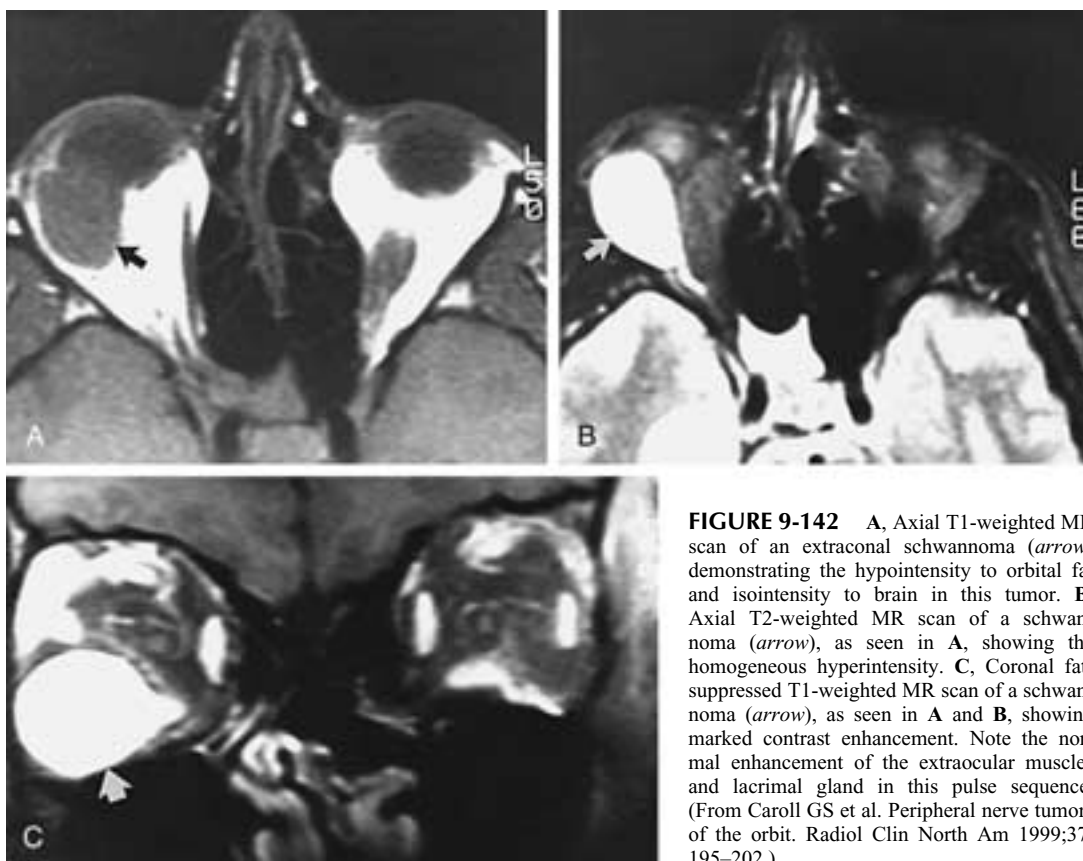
A, Axial T1-weighted MR scan of an extraconal schwannoma (arrow) demonstrating the hypointensity to orbital fat and isointensity to brain in this tumor. B, Axial T2-weighted MR scan of a schwannoma (arrow), as seen in A, showing the homogeneous hyperintensity. C, Coronal fat-suppressed T1-weighted MR scan of a schwannoma (arrow), as seen in A and B, showing marked contrast enhancement. Note the normal enhancement of the extraocular muscles and lacrimal gland in this pulse sequence. (From Carroll GS et al. Peripheral nerve tumors of the orbit. Radiol Clin North Am 1999;37:195–202.)
